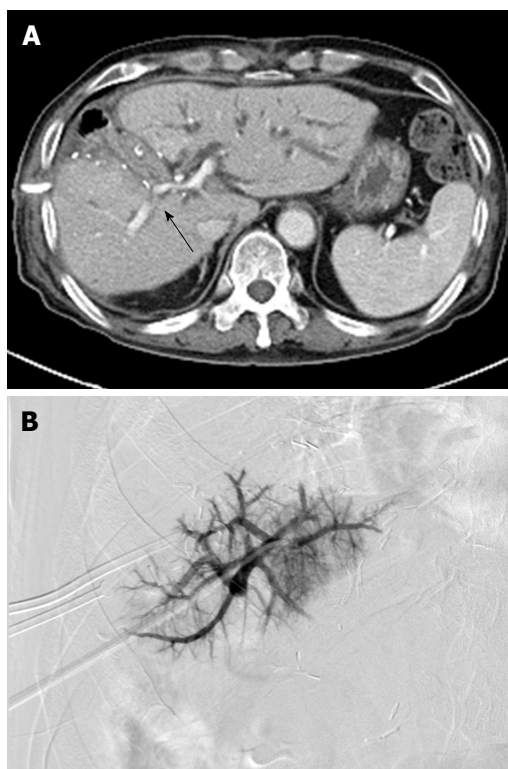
A selection failure case. A 78-year-old man (patient No. 23) presenting with right PV stenosis after hepatic central segmentectomy with liver metastasis from colon cancer. A: Axial CT scan 40 d after surgery showing severe stenosis (arrow) at the right PV. B: Percutaneous transhepatic portogram showing peripheral right PV. Main PV was not selected due to severe stenosis at the right PV. CT: Computed tomography; PV: Portal vein.
